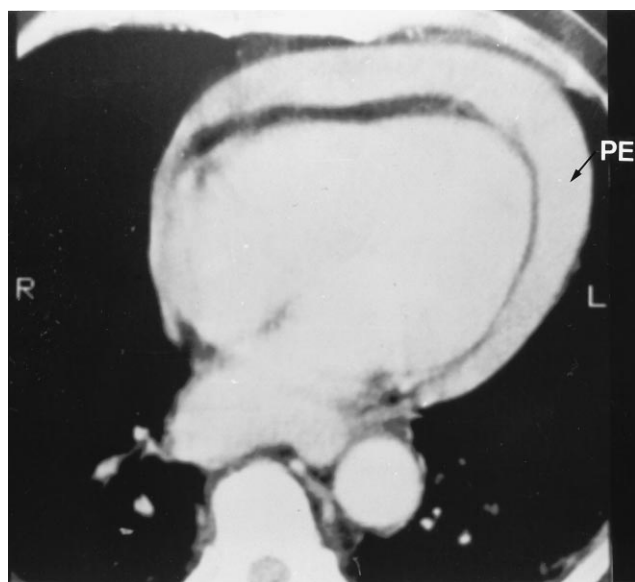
Axial computed tomographic image of a moderate to severe effusion (PE) in a 65-year old man (Patient 3) who presented with EMD in the course of a lateral myocardial infarction and who underwent life-saving pericardiocentesis (50 ml). L = left; R = right.
